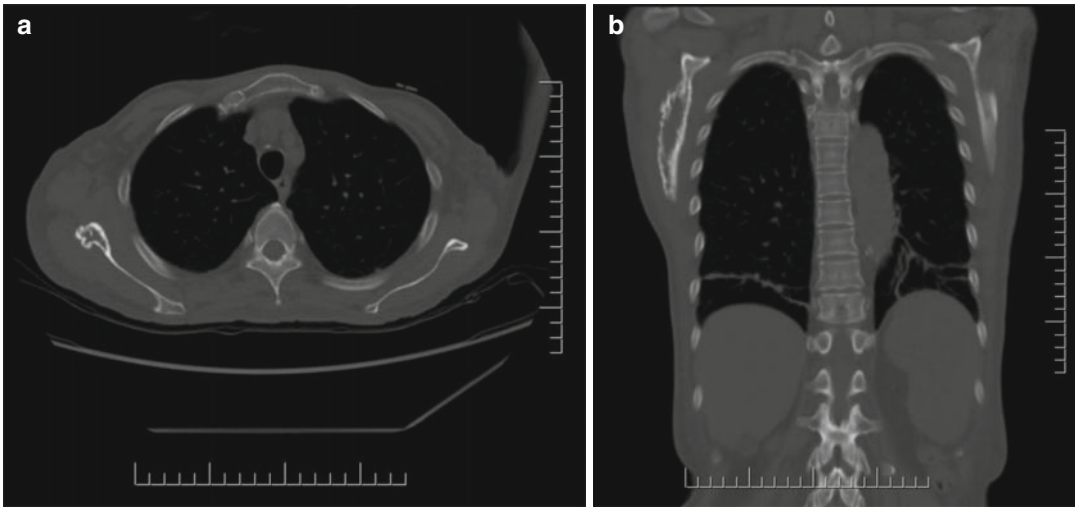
(a–c) Axial CT scan slices showing a mixed sclerotic lytic lesion in the right scapula. There was associated soft tissue swelling in the surrounding musculature
